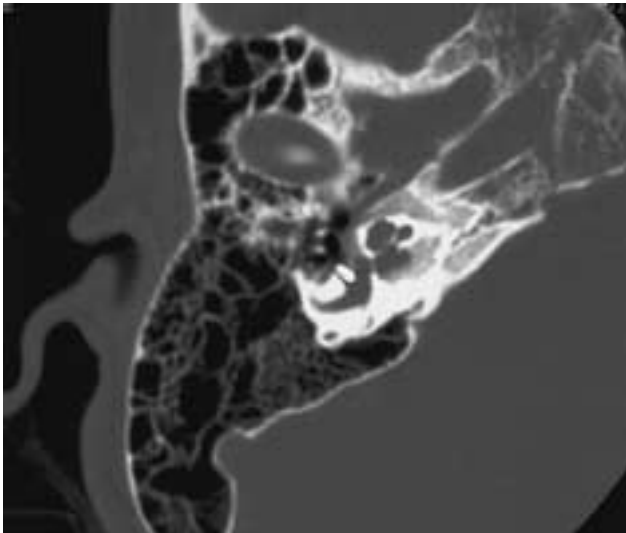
Stapes prosthesis. Axial CT image. Note the malposition of the stapes prosthesis, which is displaced medially through the oval window. The patient has severe fenestral and cochlear otosclerosis.
